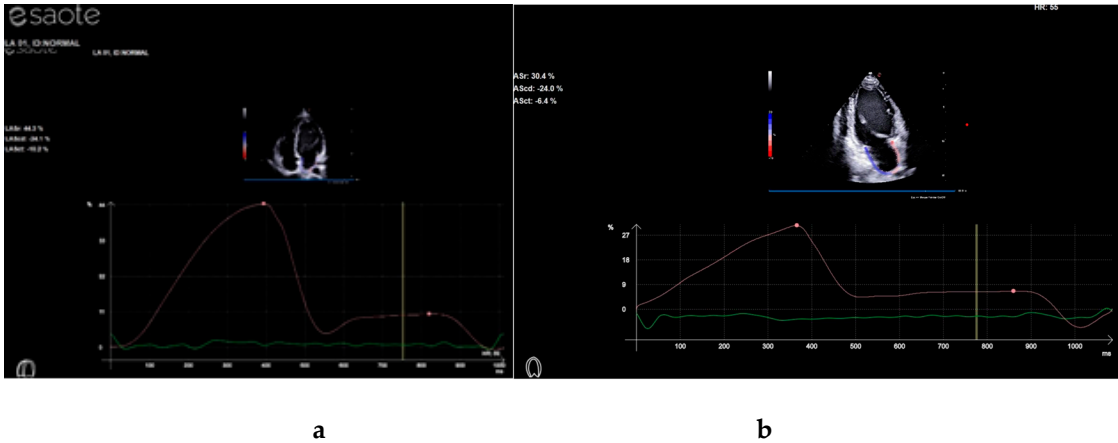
Demonstration of LA longitudinal myocardial deformation dynamics by 2-dimensional speckle-tracking echocardiography. A representative case of a subject from 4 (a) and 2 (b) chamber views. PALS indicates peak atrial longitudinal strain and PACS indicates peak atrial contraction strain.
